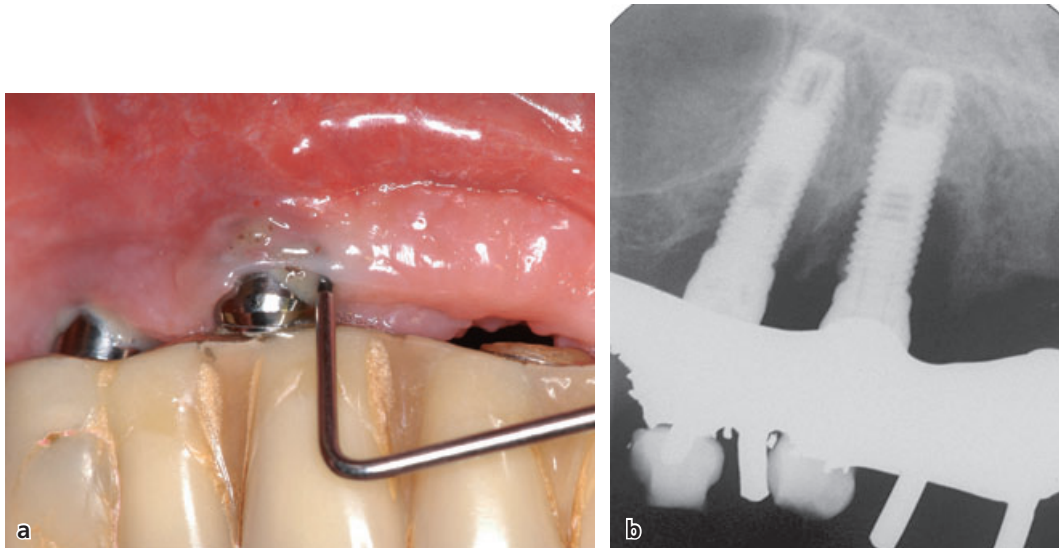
Clinical photograph from implant sites with peri-implantitis. Note the PPD of 10 mm and suppuration (a) and the crater-formed defects in the radiograph (b).
